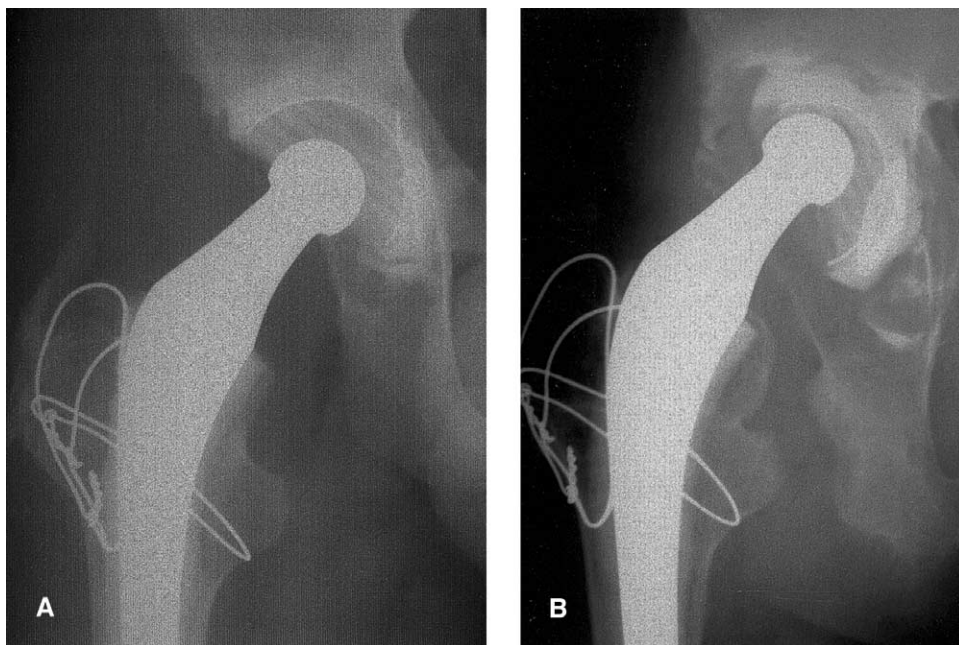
(A) Immediate post-operative and (B) follow-up radiograph taken at 20 years and 3 months postoperatively. The acetabular component is loose with evidence of migration of more than 5 mm.
